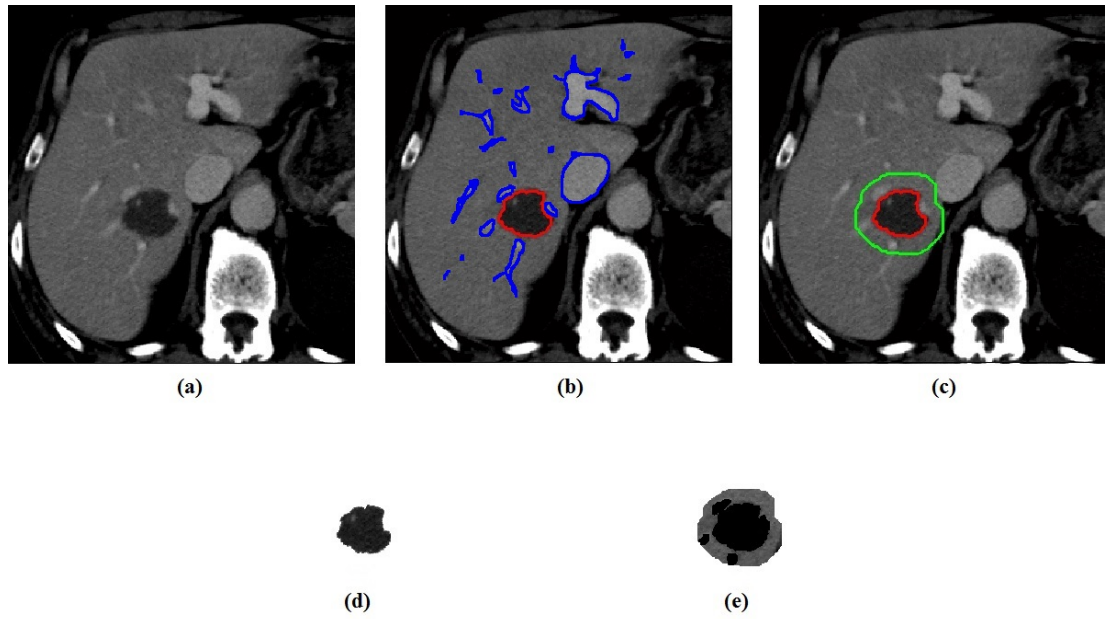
Proposed framework for Lesion and normal liver tissue ROI selection; (a) Original CT image; (b) Liver lesion and vessels detection; (c) First ROI is red border for segmented lesion and second ROI is green border for surrounding normal liver tissue; (d) Actual segmented lesion; (e) Normal liver tissue excluding lesion area and liver vessels.
